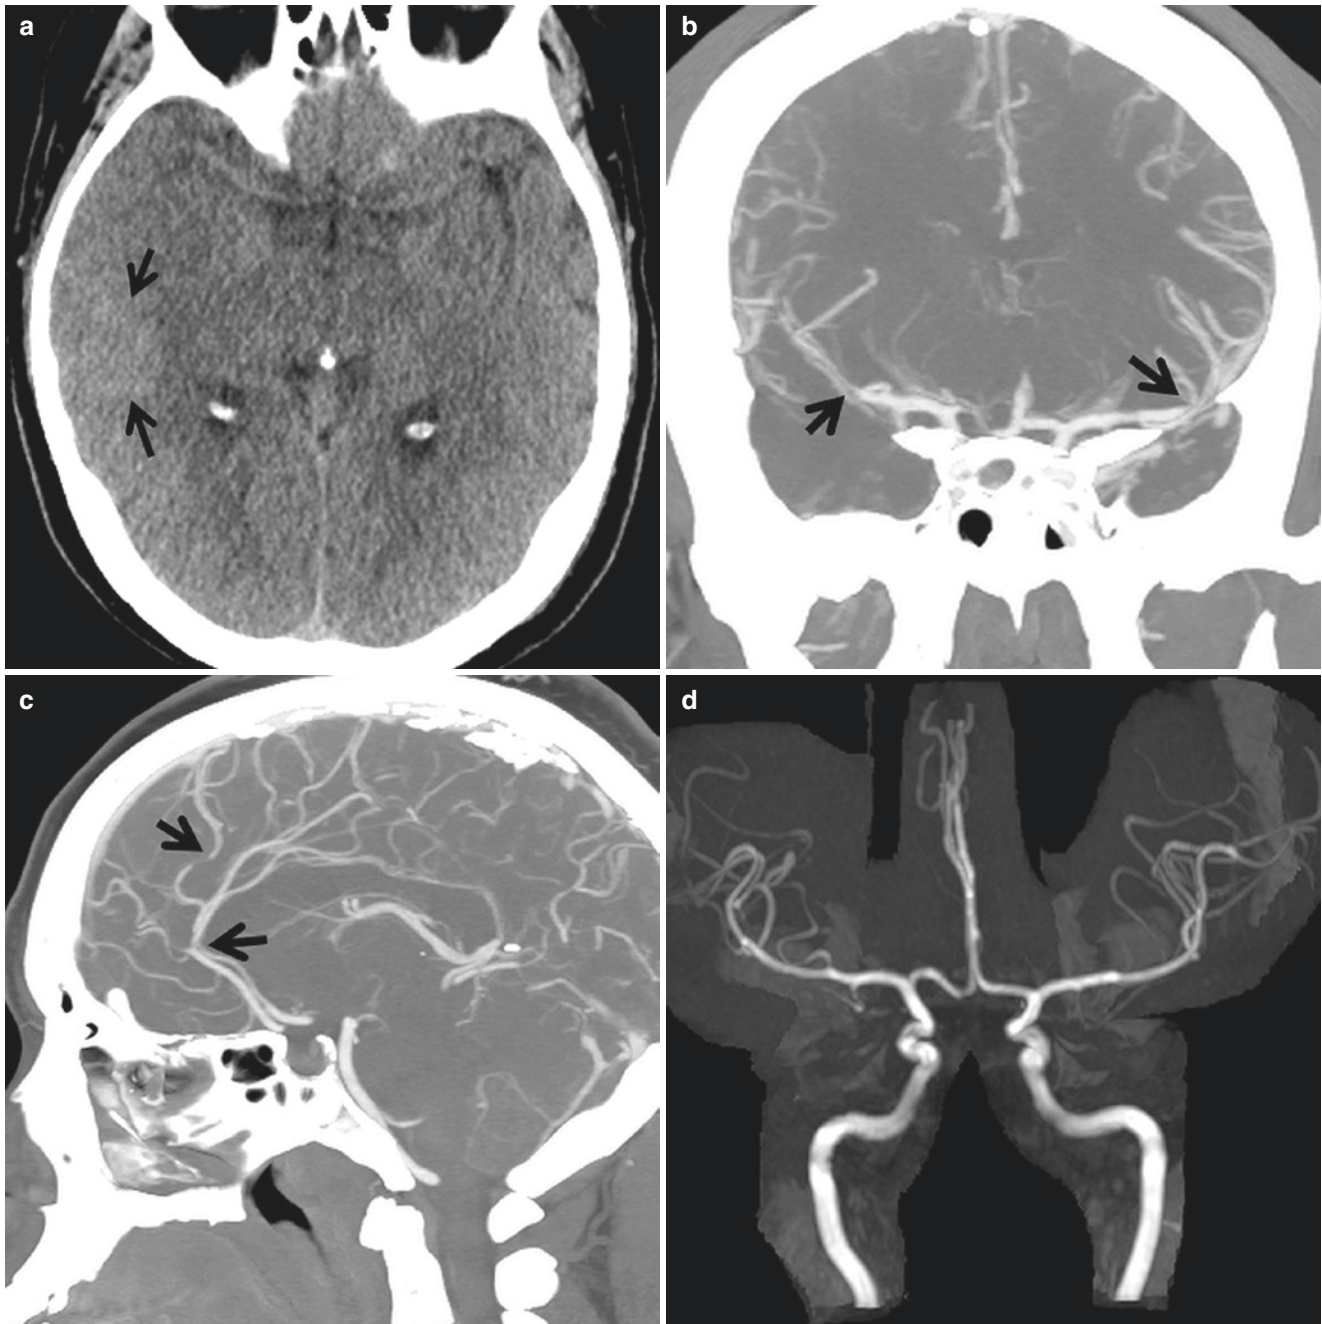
Reversible cerebral vasoconstriction syndrome. A 24-year-old presents with thunderclap headache. (a) NCCT shows small subarachnoid hemorrhage in the right temporal sulci. (b) CTA coronal MIP shows narrowing of the bilateral MCA M2 segments (arrows). (c) CTA
